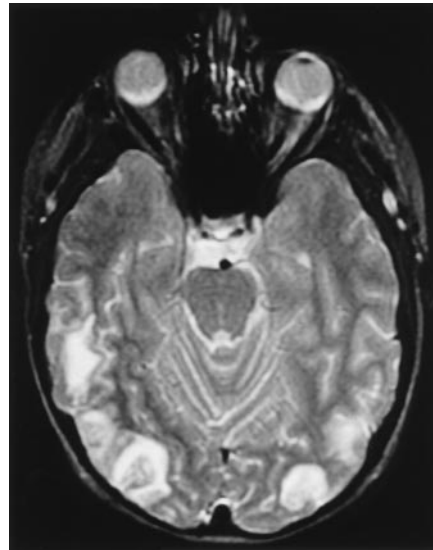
Brain magnetic resonance imaging demonstrating multiple white matter lesions with T_2 -weighted signal involving the frontal, parietal, and occipital regions. The persistence of these lesions on follow-up T_1 -weighted scans is consistent with a vasculitic process.
